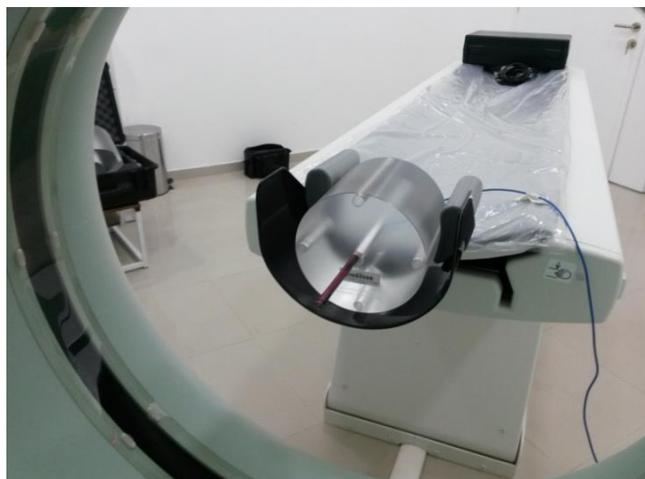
Positioned CT pencil ionization chamber (PTW TM30009)
